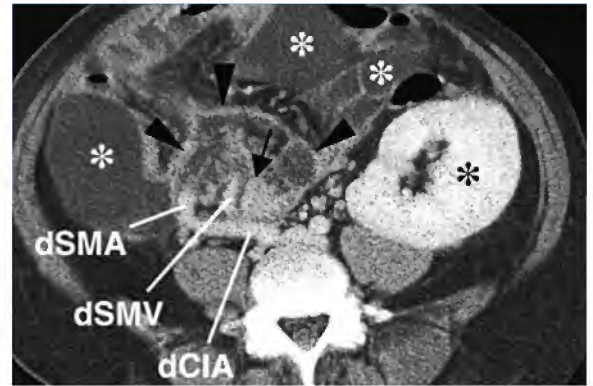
Image from a 51-year-old man obtained 4 weeks after simultaneous pancreas–kidney transplantation. Contrast-enhanced multidetector CT shows edematous swelling of donor's remaining mesenteric fat (*arrows*) and lymph nodes (*white asterisk*) attached to unremarkable, homogeneous contrast-enhancing pancreatic graft (*arrow*). Condition presumably results from ligature of donor's lymphatic vessels. CT also shows normal enhancement of donor's (*d*) vessels including superior mesenteric artery (SMA), external iliac artery (EIA), splenic artery (SA) and renal graft (*black asterisk*)
